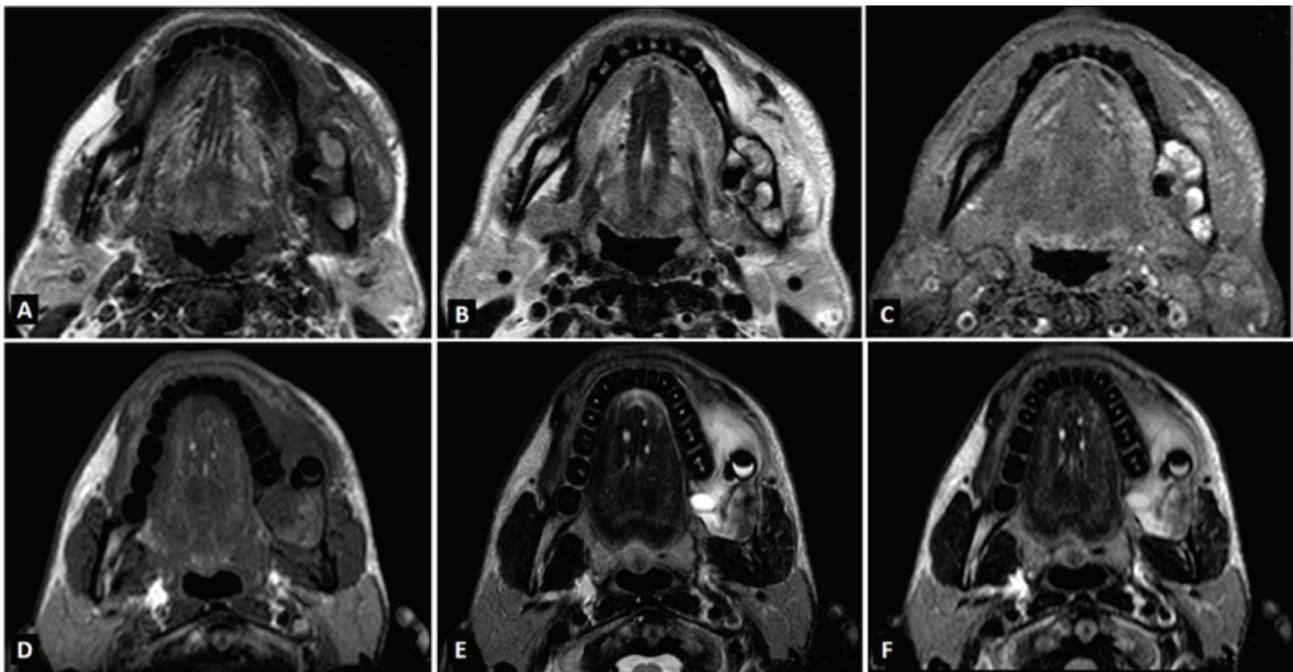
MRI: A- case 1, isointense homogeneous tumor; B and C- case 1, heterogeneous isointense and hyperintense areas; D- case 2 homogeneous isointense tumor; E and F- case 2, heterogeneous isointense and hyperintense areas.
